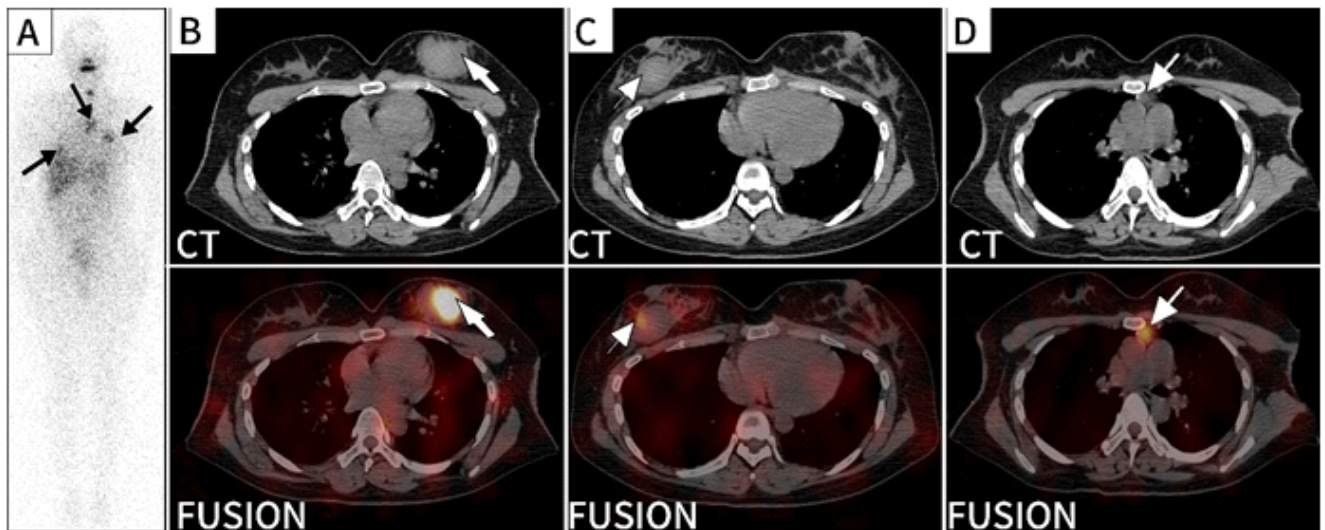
A 33-year-old woman underwent total thyroidectomy and neck lymph node dissection for papillary thyroid cancer. After thyroid hormone withdrawal, she received radiotherapy with iodine-131 (^{131}I) at a dose of 3.70GBq. The whole body scan obtained 7 days after ^{131}I administration revealed multifocal increased activity in the thyroid region and the chest (A, arrows). Subsequent single photon emission tomography/computed tomography (SPECT/CT) images of the chest were acquired to localize radioactivity. The axial images showed soft tissue masses (3.8cmx4.2cm in left breast, 3.5cmx3.0cm in right breast) in bilateral breasts with heterogeneous activity (B-C, arrows). The right mass had much higher activity comparing to the left mass. The axial image revealed elevated ^{131}I uptake in thymus, approximately 1.1cmx1.0cm in size, without any obvious mass lesion (D, arrows). Laboratory examination revealed TG 0.85ng/mL and TGA 14.16U/mL. However, lesions in bilateral breasts could not be excluded as metastases from thyroid cancer or primary breast tumors.
